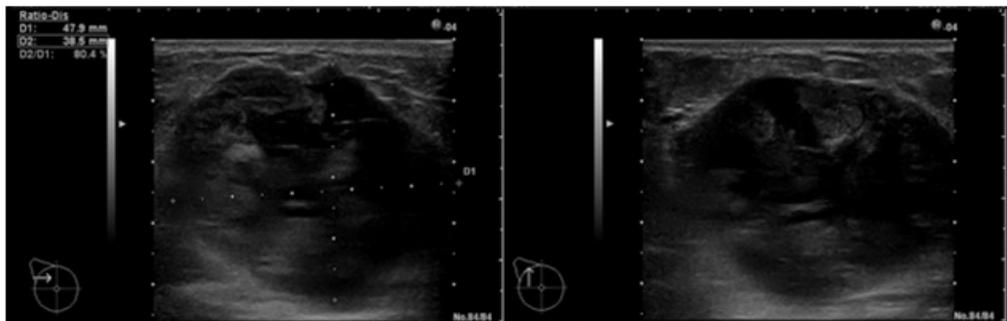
Sonography of both transverse (left) and sagittal (right) scan revealed smooth and well circumscribed round tumor, heterogenous internal echo partly showing hypoechoic regions with an echogenic rim. Maximum diameter being in the transverse plane 47,8mm. Intracystic tumor was speculated.
